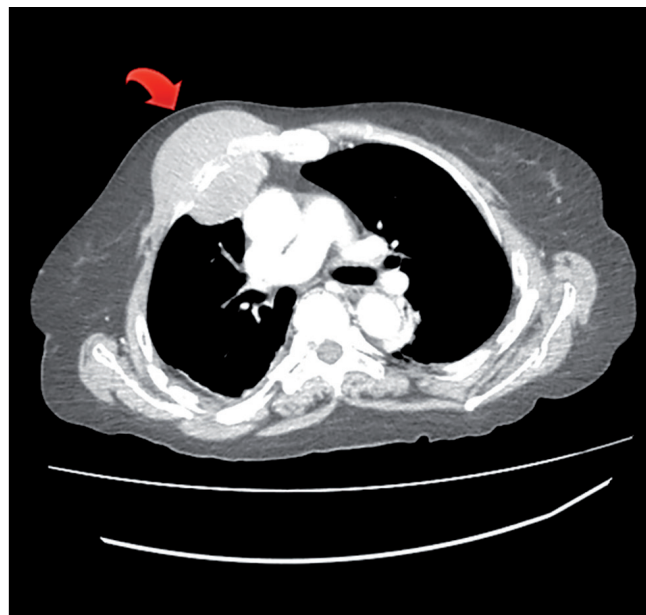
The soft tissue mass on the anterior chest wall invading the rib on the mediastinal window of thorax CT.
